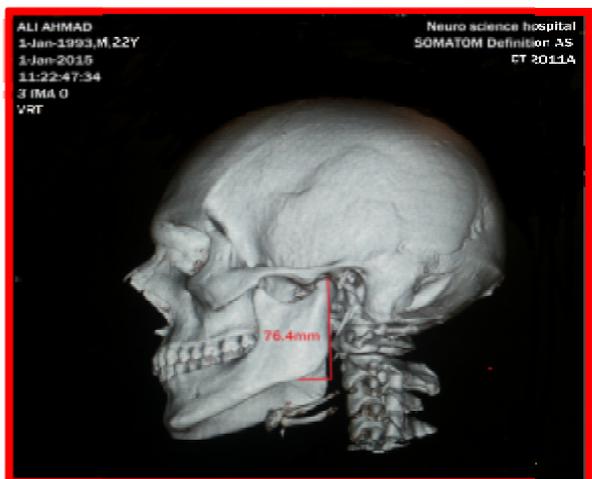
Linear measurements of condylar height (Max MRB) by 3D reconstructed computed tomography image in sagittal section
